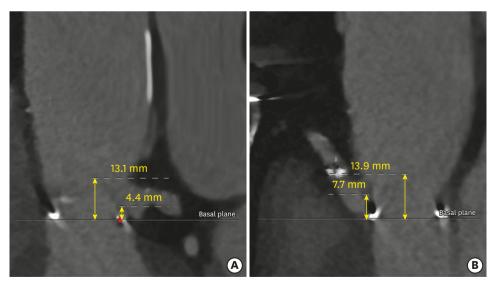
Heights of coronary ostia and sinus of Valsalva measured in reconstructed computed tomography imaging. Coronary ostium height was defined as vertical distance between neo-annulus to coronary ostium. Sinus of Valsalva height was defined as vertical distance between neo-annulus to sinotubular junction. (A) denotes coronary height from neo-annulus to left coronary ostium (short arrow, 4.4 mm) and sinus of Valsalva height from left coronary cusp side (long arrow, 13.1 mm). (B) denotes coronary height from neo-annulus to right coronary ostium (short arrow, 7.7 mm) and sinus of Valsalva height from right coronary cusp side (long arrow, 13.9 mm).
